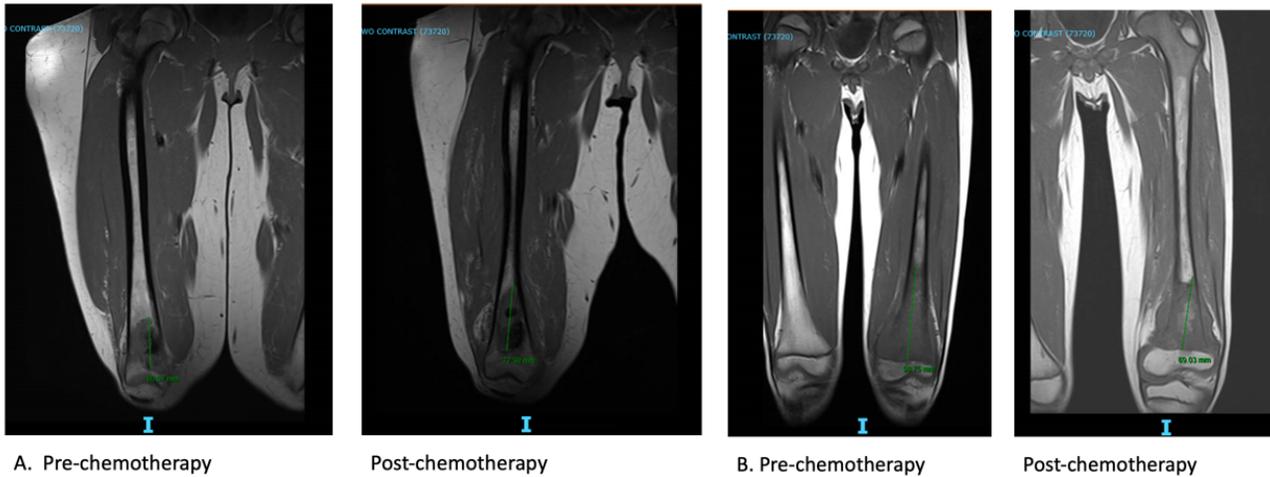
Measurements of tumor size in greatest dimension on MRI of femur of two patients. (A) MRI shows an increase in the greatest dimension of the tumor after neoadjuvant chemotherapy. (B) MRI shows a decrease in the greatest dimension of the tumor after neoadjuvant chemotherapy.
